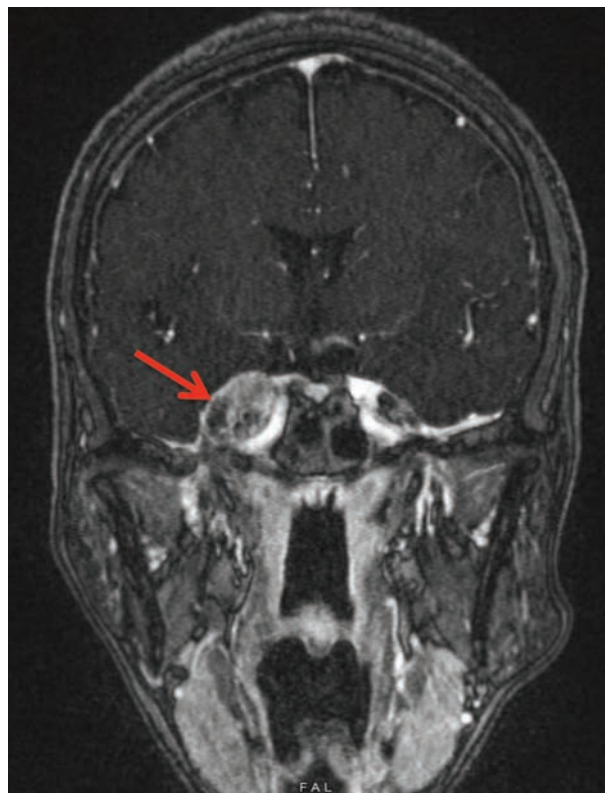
This is our patient's FLAIR MRI with contrast of the head. The red arrow is pointing to the 2.1x1.6x2.4cm peri-sphenoid lesion abutting the right cavernous sinus and involving right Meckel's cave
